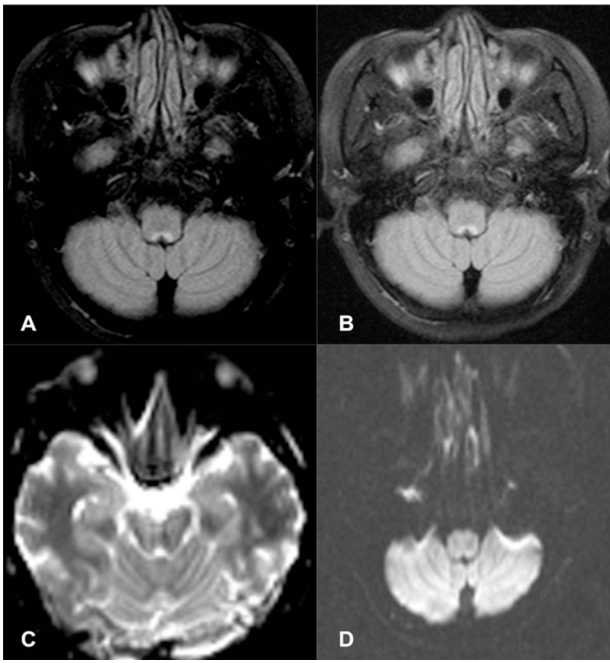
T2-weighted (A), T2-FLAIR (B), ADC (C) and DWI (D) MRI sequences in transverse sections indicating the involved area in the AP. ADC: apparent diffusion coefficient; dwi: diffusion-weighted imaging; FLAIR: fluid-attenuated inversion recovery; MRI: magnetic resonance imaging.
